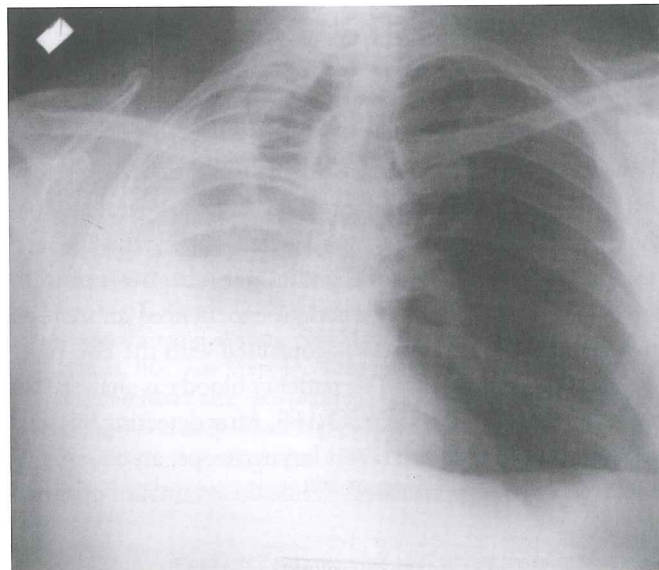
Chest X-ray after tube removal.
